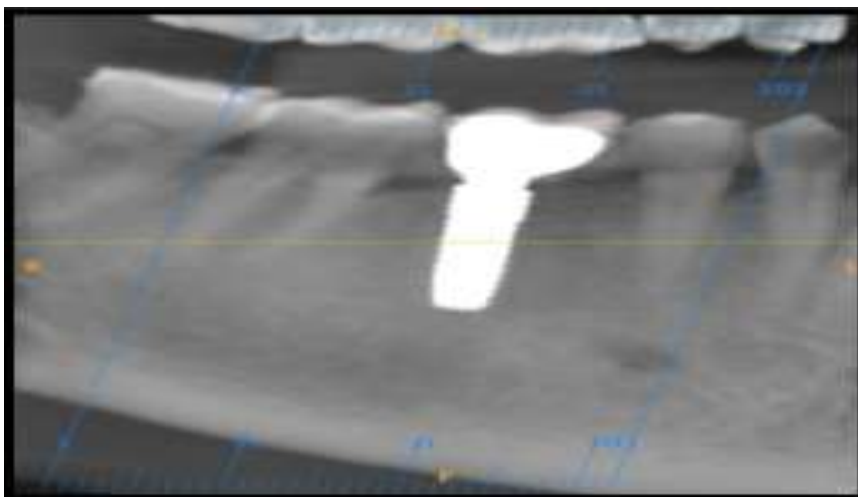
Post loading CBCT, 46 Region
